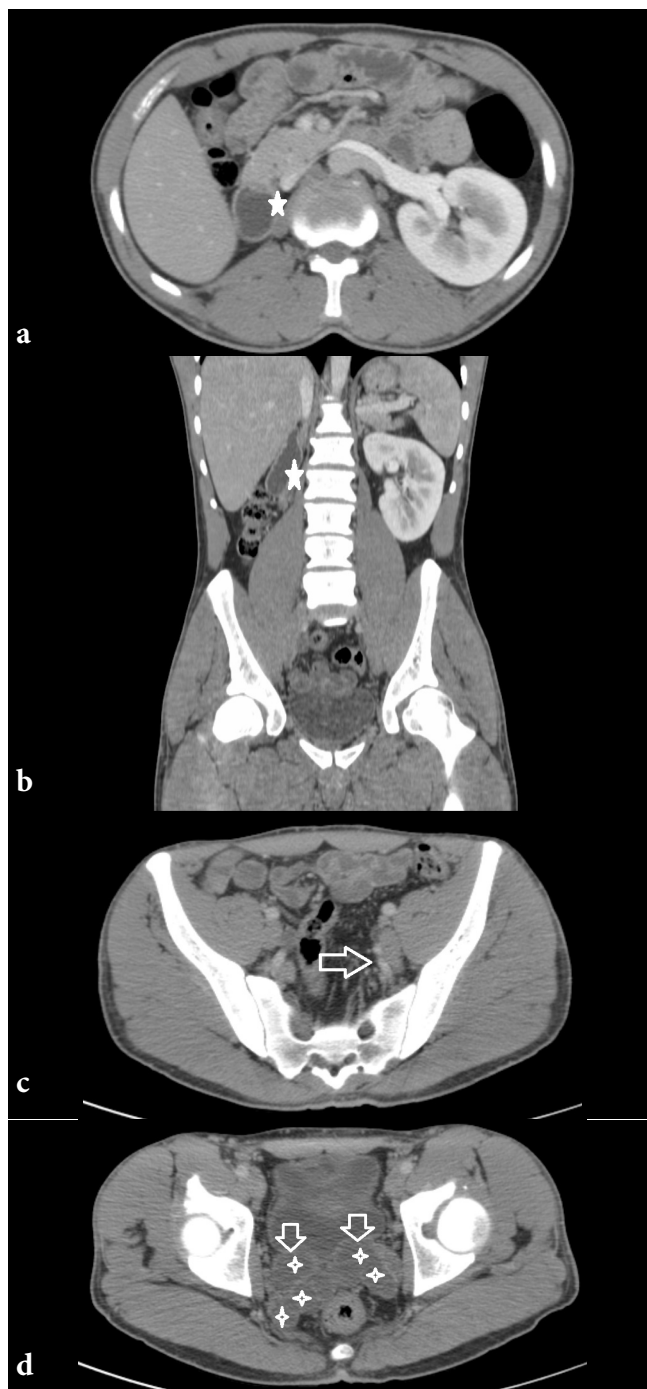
In CT examination; Right kidney agenesis is observed (a-b). In the left side of the pelvic region, there is an increase in pelvic vascularity (c) and an expansion in the cystic tubular structure at the level of the seminal vesicle (d).
